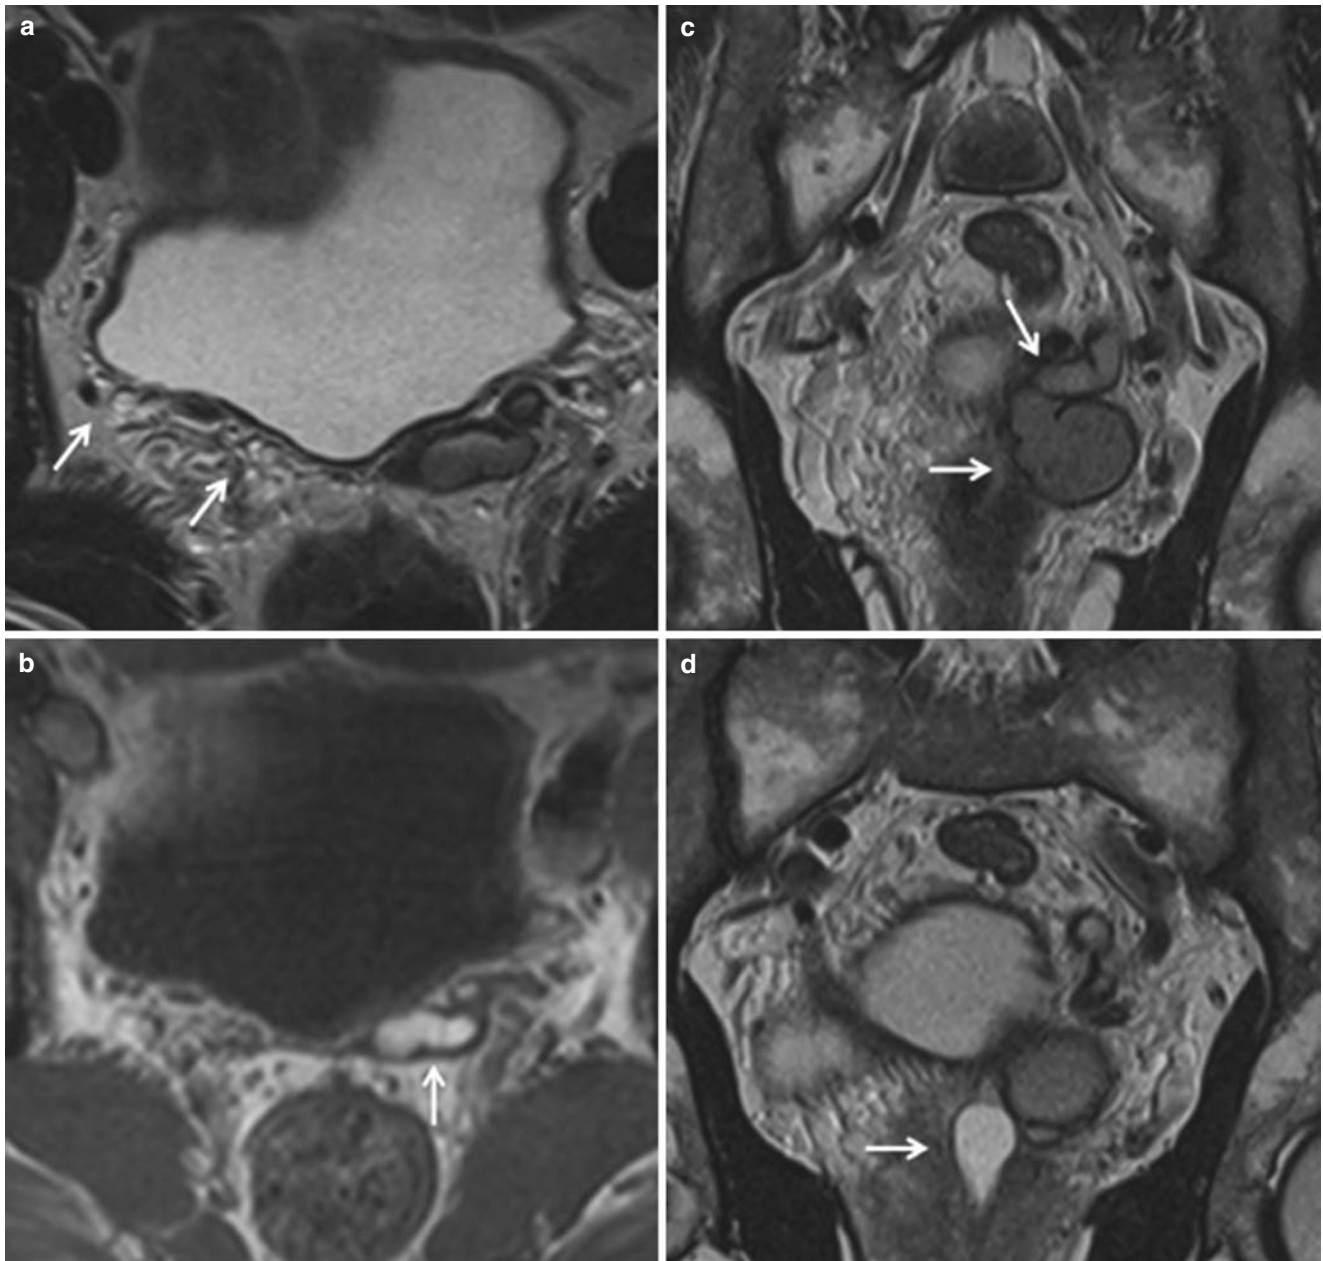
Agenesis of the SV and vas deferens (VD) in a 35-year-old man with infertility and hematospermia. Axial (a) T2-weighted MR image shows right absence of the SV and VD (arrows). Axial (b) T1-weighted MR image shows high signal intensity within the left vas
